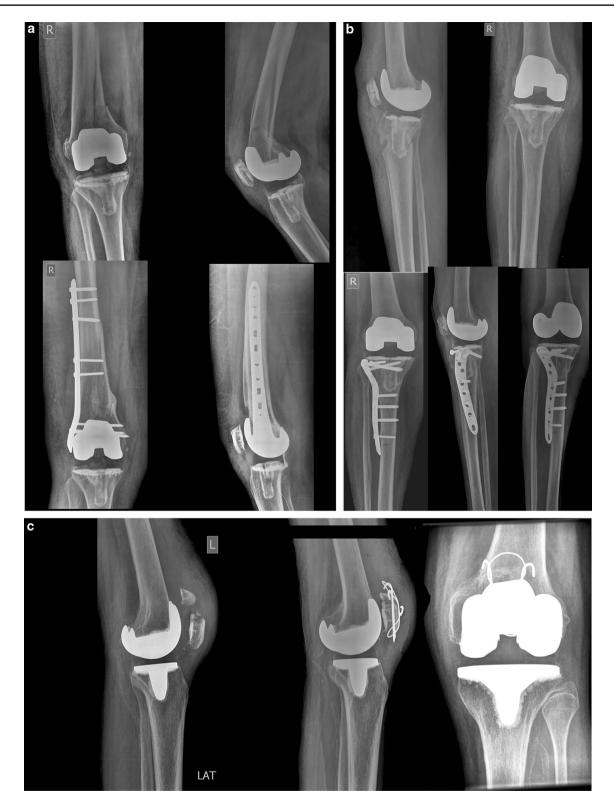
Postoperative X-rays. a Femur Rorabeck type 2 fracture fixed with anatomical LCP, b tibia Felix type 2 fracture fixed with anatomical LCP and c patella Goldberg type 2 fracture fixed with TBW
